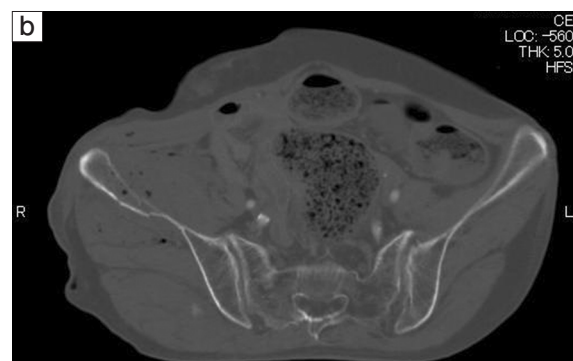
a : A 3D-CT image of the pelvis on the day of admission. The CT showed pubis and ischium fractures and a right iliac fracture.
